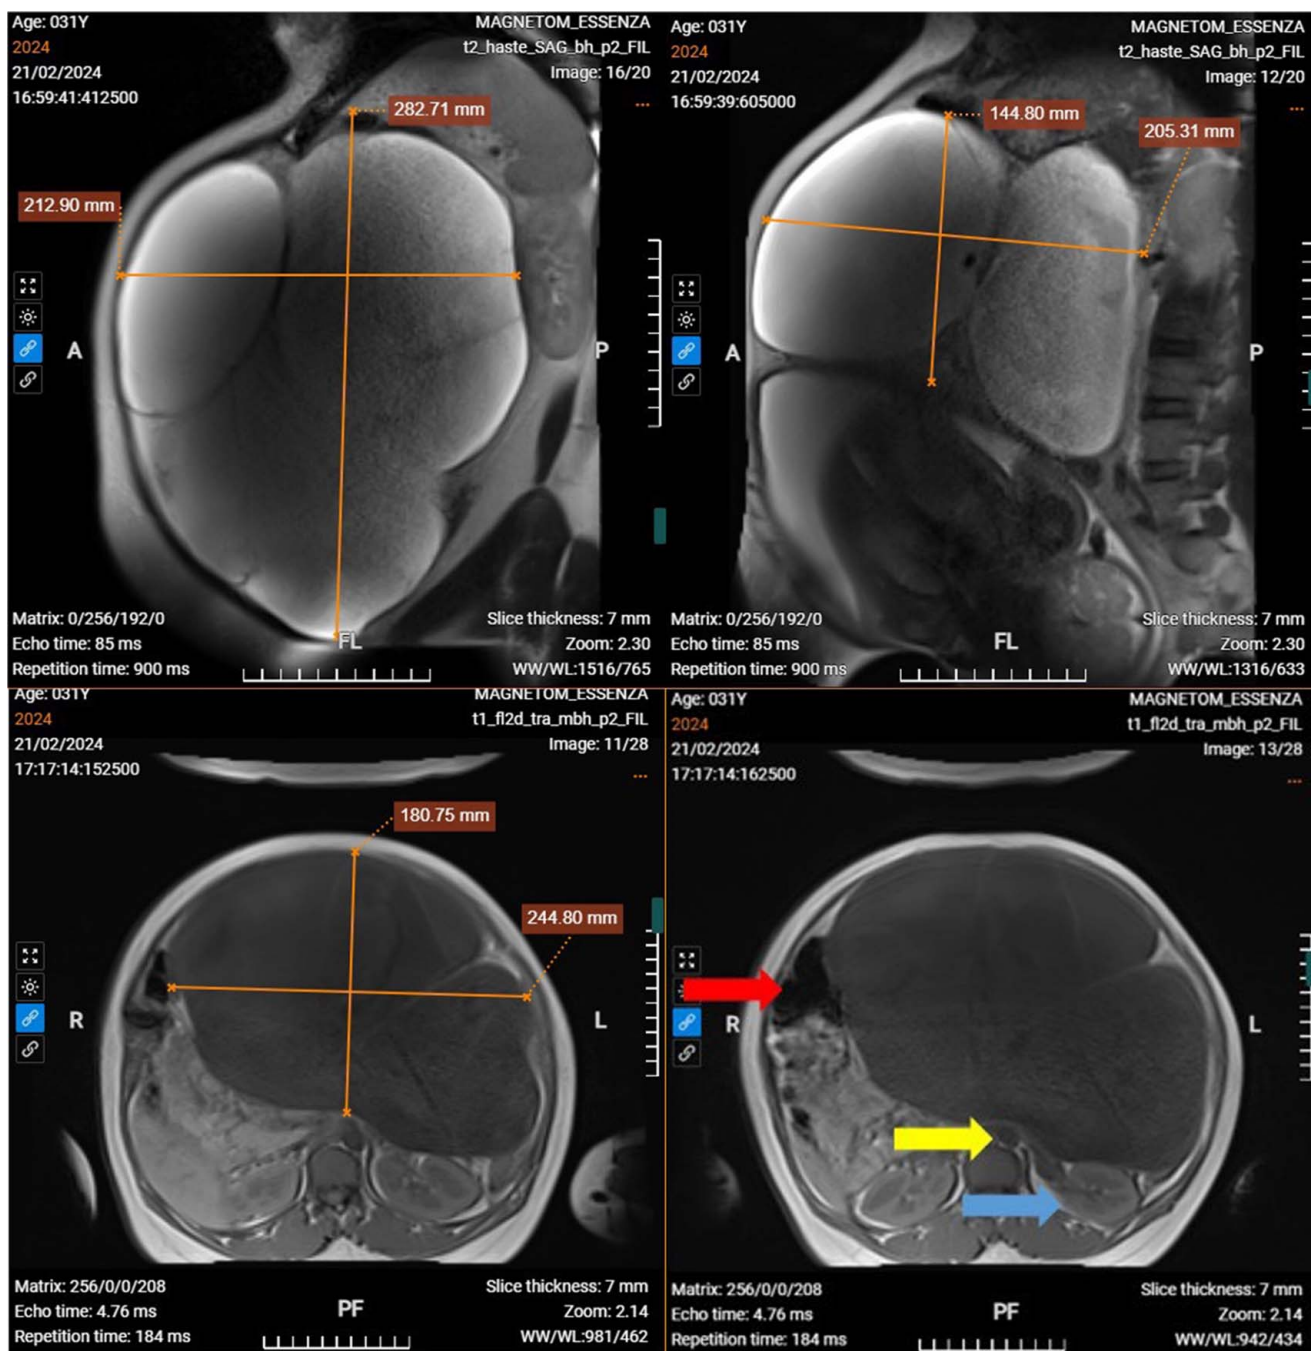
Abdominal MRI showed a giant ovarian tumor at 38 weeks of pregnancy that pressed on adjacent structures (red arrow: colon corner, green arrow: left kidney, yellow arrow: aorta).
